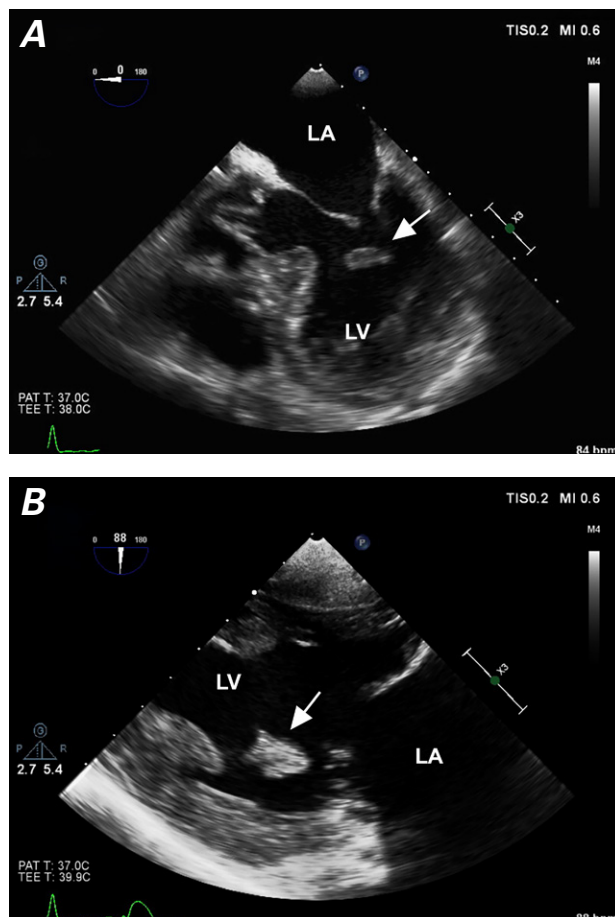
Transesophageal echocardiograms in A) mid-esophageal 4-chamber and B) transgastric 2-chamber diastolic views show the ruptured papillary muscle fragment (arrow).
